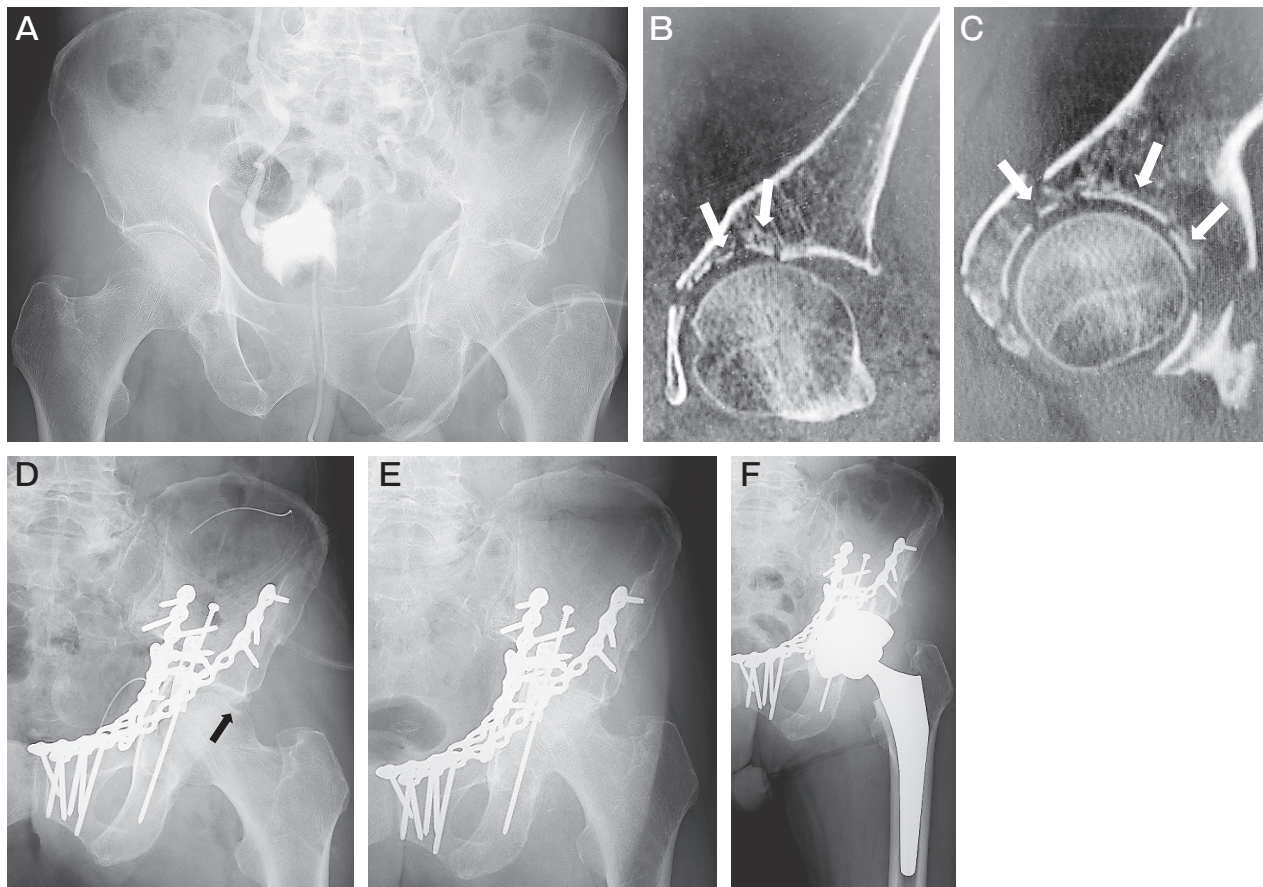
Images of the clinical course in the left hip joint of a 66-year-old man who sustained a T-shaped acetabular fracture. A, An anteroposterior radiograph at the injury; B,C, CT images at the injury showed severely comminuted RI fragments on the weight-bearing surface (*white arrows*); D, An anteroposterior radiograph after surgery using the modified ilioinguinal approach. A femoral head injury was also observed (*black arrow*); E, An anteroposterior radiograph at 5 months post-surgery showed severe joint-space narrowing; F, An anteroposterior radiograph after the patient's total hip arthroplasty.
